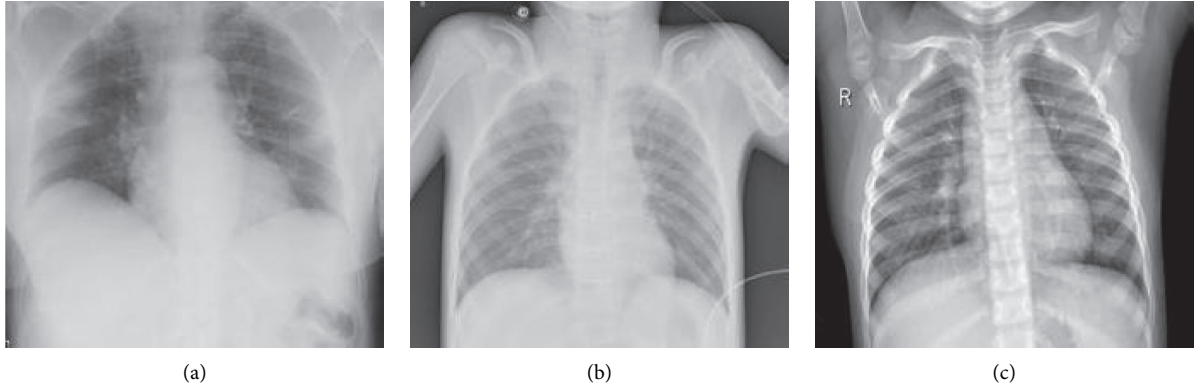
Chest X-ray images of the different conditions: (a) COVID-19; (b) pneumonia; (c) healthy.
